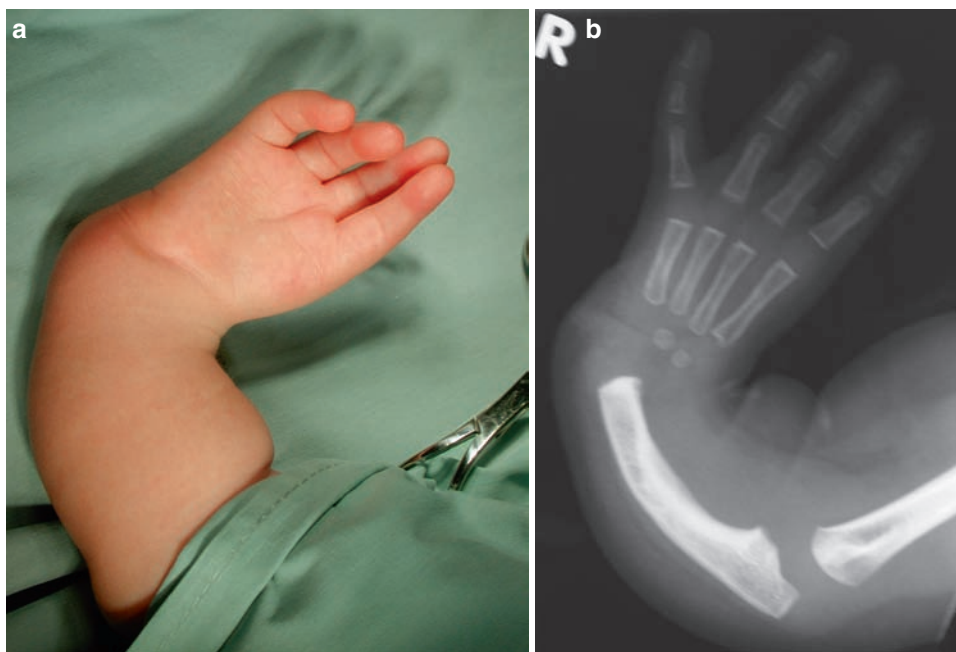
(a) Radial club hand with Blauth V thumb hypoplasia. (b) Radiograph of type IV radial club hand.
